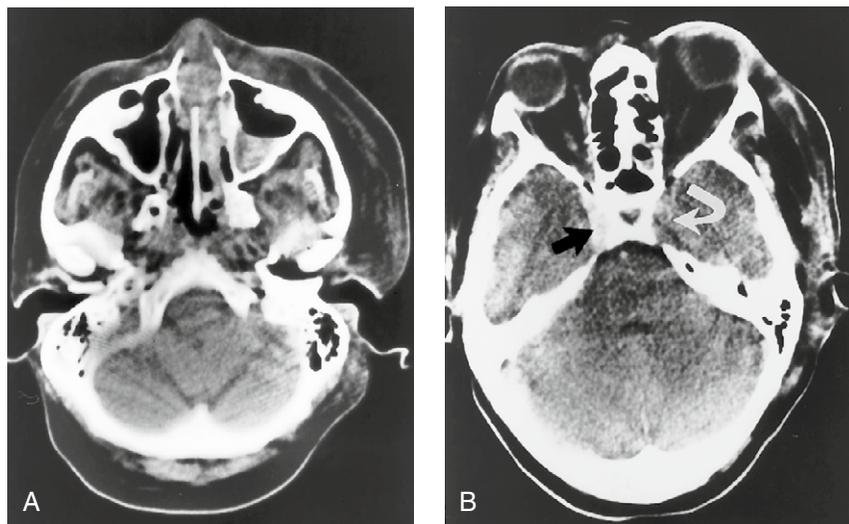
Rhinocerebral zygomycosis with cavernous sinus thrombosis. (A) Axial CT scan through the maxillary sinuses shows an air–fluid level in the left maxillary sinus and swelling of the left facial soft tissues. (B) Enhanced CT scan shows normal enhancement of the right cavernous sinus (black arrow) and no enhancement of the thrombosed left cavernous sinus (white curved arrow).
